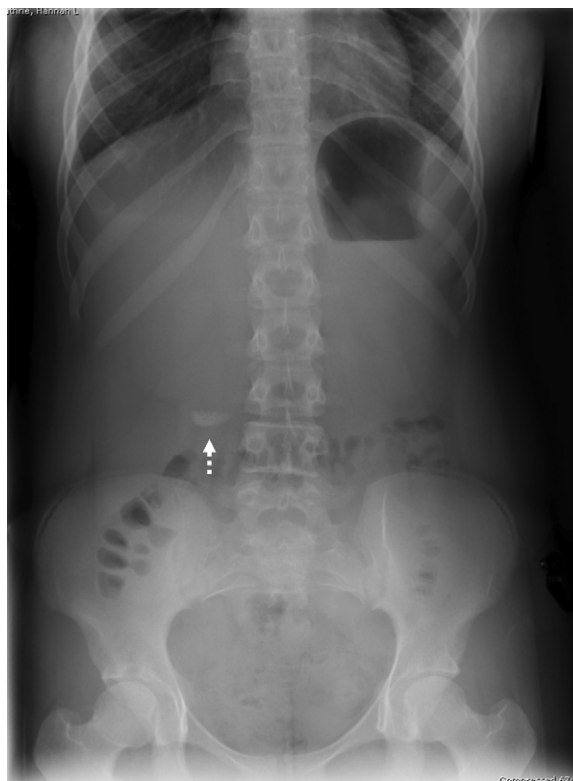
This 9-year-old girl developed nausea and right upper abdominal pain. This plain radiograph revealed calcified gallstones (arrow) that had settled in the dependent portion of the gallbladder on this upright abdominal film.
